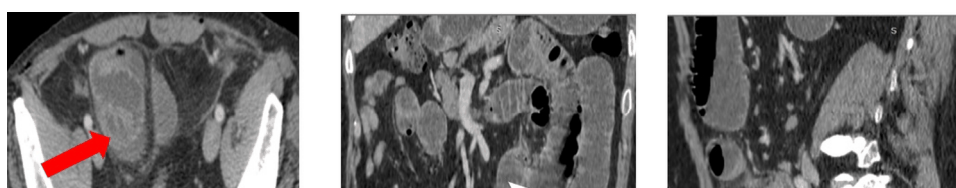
CT scan images on axial (A), coronal (B) and sagittal (C) planes showing proximal and distal small bowel obstruction (White arrows) with a transitional zone in the right lower abdomen with a cluster of bowel loops (Red arrows) within a hernia sac occupying the right supra-vesical fossa
